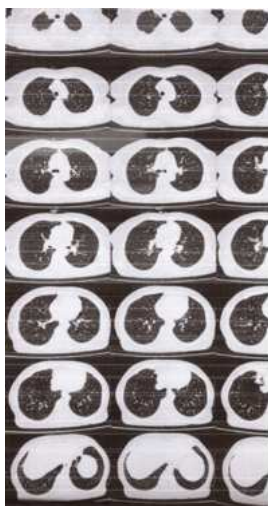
HRCT Chest (Sagittal Section)
